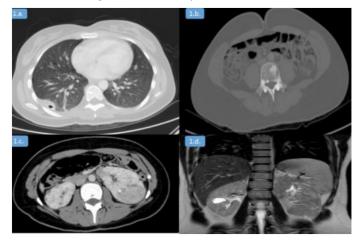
Thorax CT, paraseptal emphysema regions in both lungs, ground-glass densities and mosaic pattern. 1b: Abdominal CT sections, sclerotic tubular formations in the body of lumbar vertebra. 1 c. d: Dynamic MRI examination, angiomyolipomas like solid masses (isointense in T2) in both kidneys that have peripheral contrast retention in the CT with contrast, para-medullary cortical cysts.
